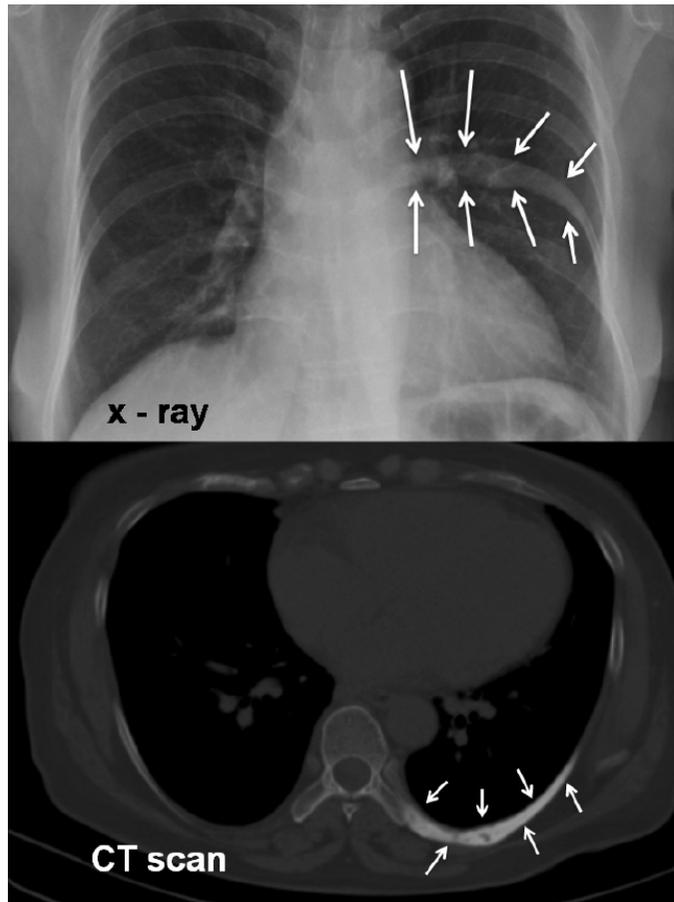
Chest X-ray (upper panel) revealing a hyperdense lesion in the left 8th rib (arrows); the computed tomography scan of the chest (lower panel, arrows) documented the abnormality.
